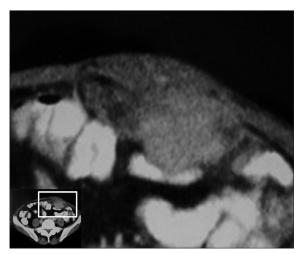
Computed tomography scan demonstrates the tumor originating from the abdominal transversal and internal oblique muscle fascia
